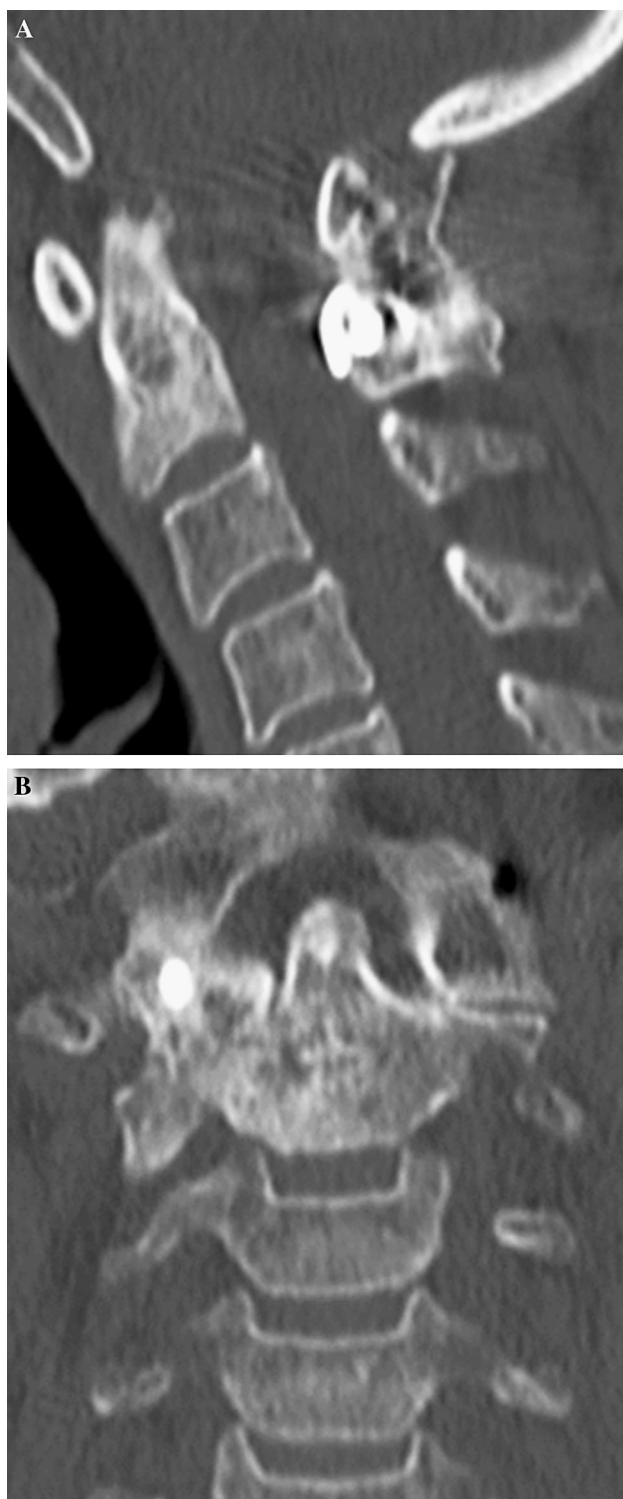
CT 6 months after the surgery. Transplanted autograft was completely fused. Additionally, the right atlantoaxial joint space was completely fused without bone grafting, maintaining distracted alignment in the coronal plane. a Sagittal view. b Coronal view
